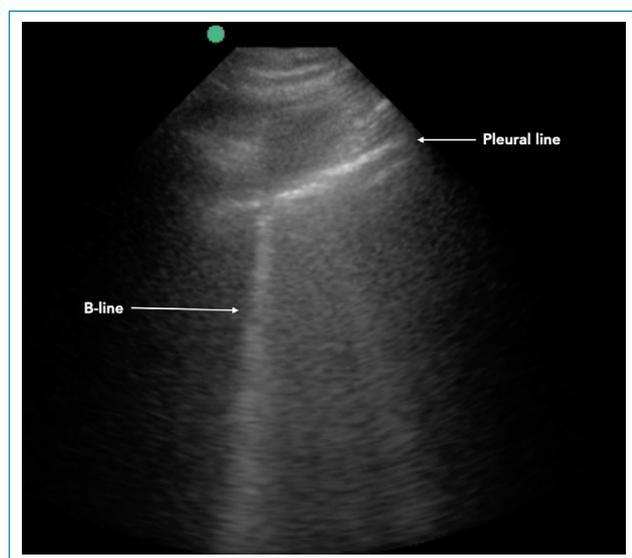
Lung ultrasound from a patient with COVID-19 showing an irregular and fragmented pleural line from which a B-line originates.
